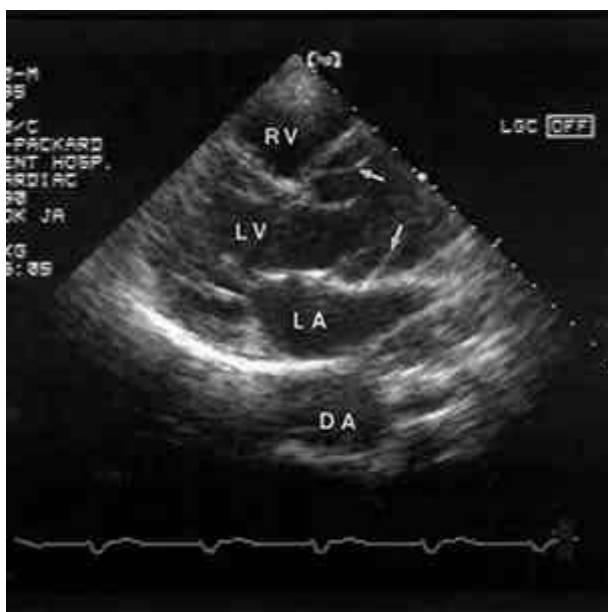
Transthoracic echocardiography revealing aorta aneurysm involving the aortic root with intimal flap (arrows) and dilated descending thoracic aorta in the parasternal long axis view. DA=descending thoracic aorta; LA=left atrium; LV=left ventricle; RV=right ventricle.
